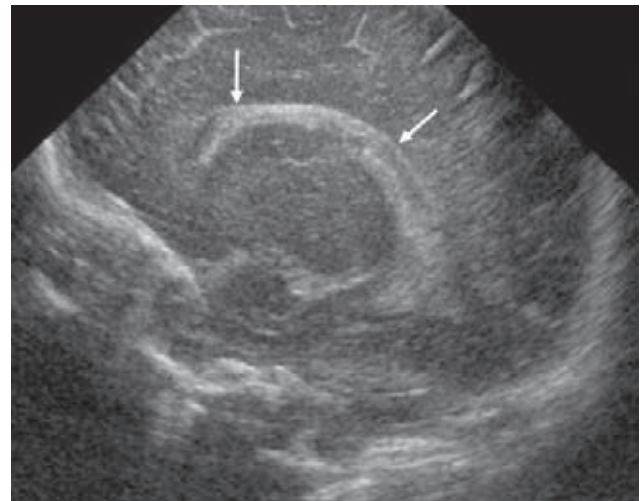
Grade 2 intraventricular haemorrhage. Left parasagittal ultrasound scan shows blood within the left lateral ventricle (arrows). The ventricle is not dilated
